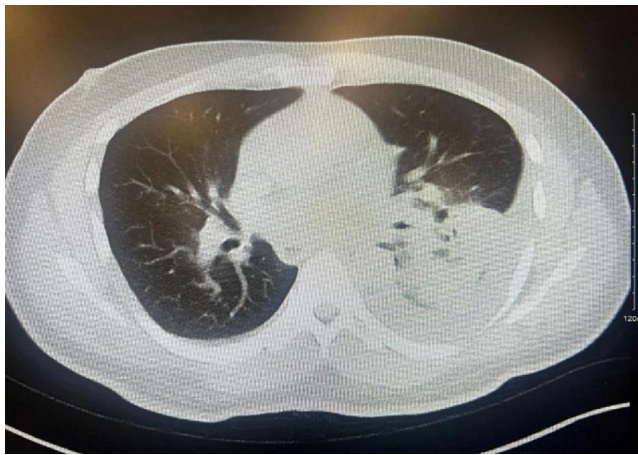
Chest CT showing unresolved left lower lobe opacity. Axial chest CT performed in August 2024 demonstrates persistent consolidation in the left lower lobe despite appropriate antibiotic therapy, raising concern for non-resolving pneumonia and prompting further investigation.
